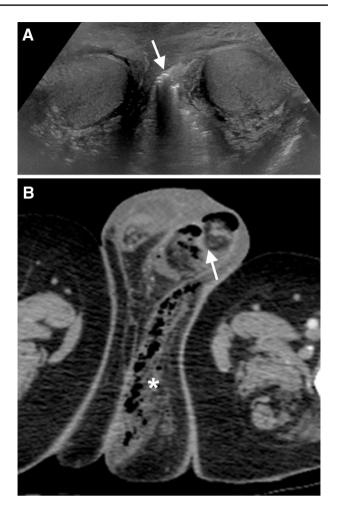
Fournier gangrene in the US. a US image shows bilateral scrotal wall edema with multiple hyperechoic foci of gas in the left hemiscrotum (arrow). b Axial enhanced CT images confirm soft tissue gas in left hemiscrotum (arrow) and left perineum (*)
